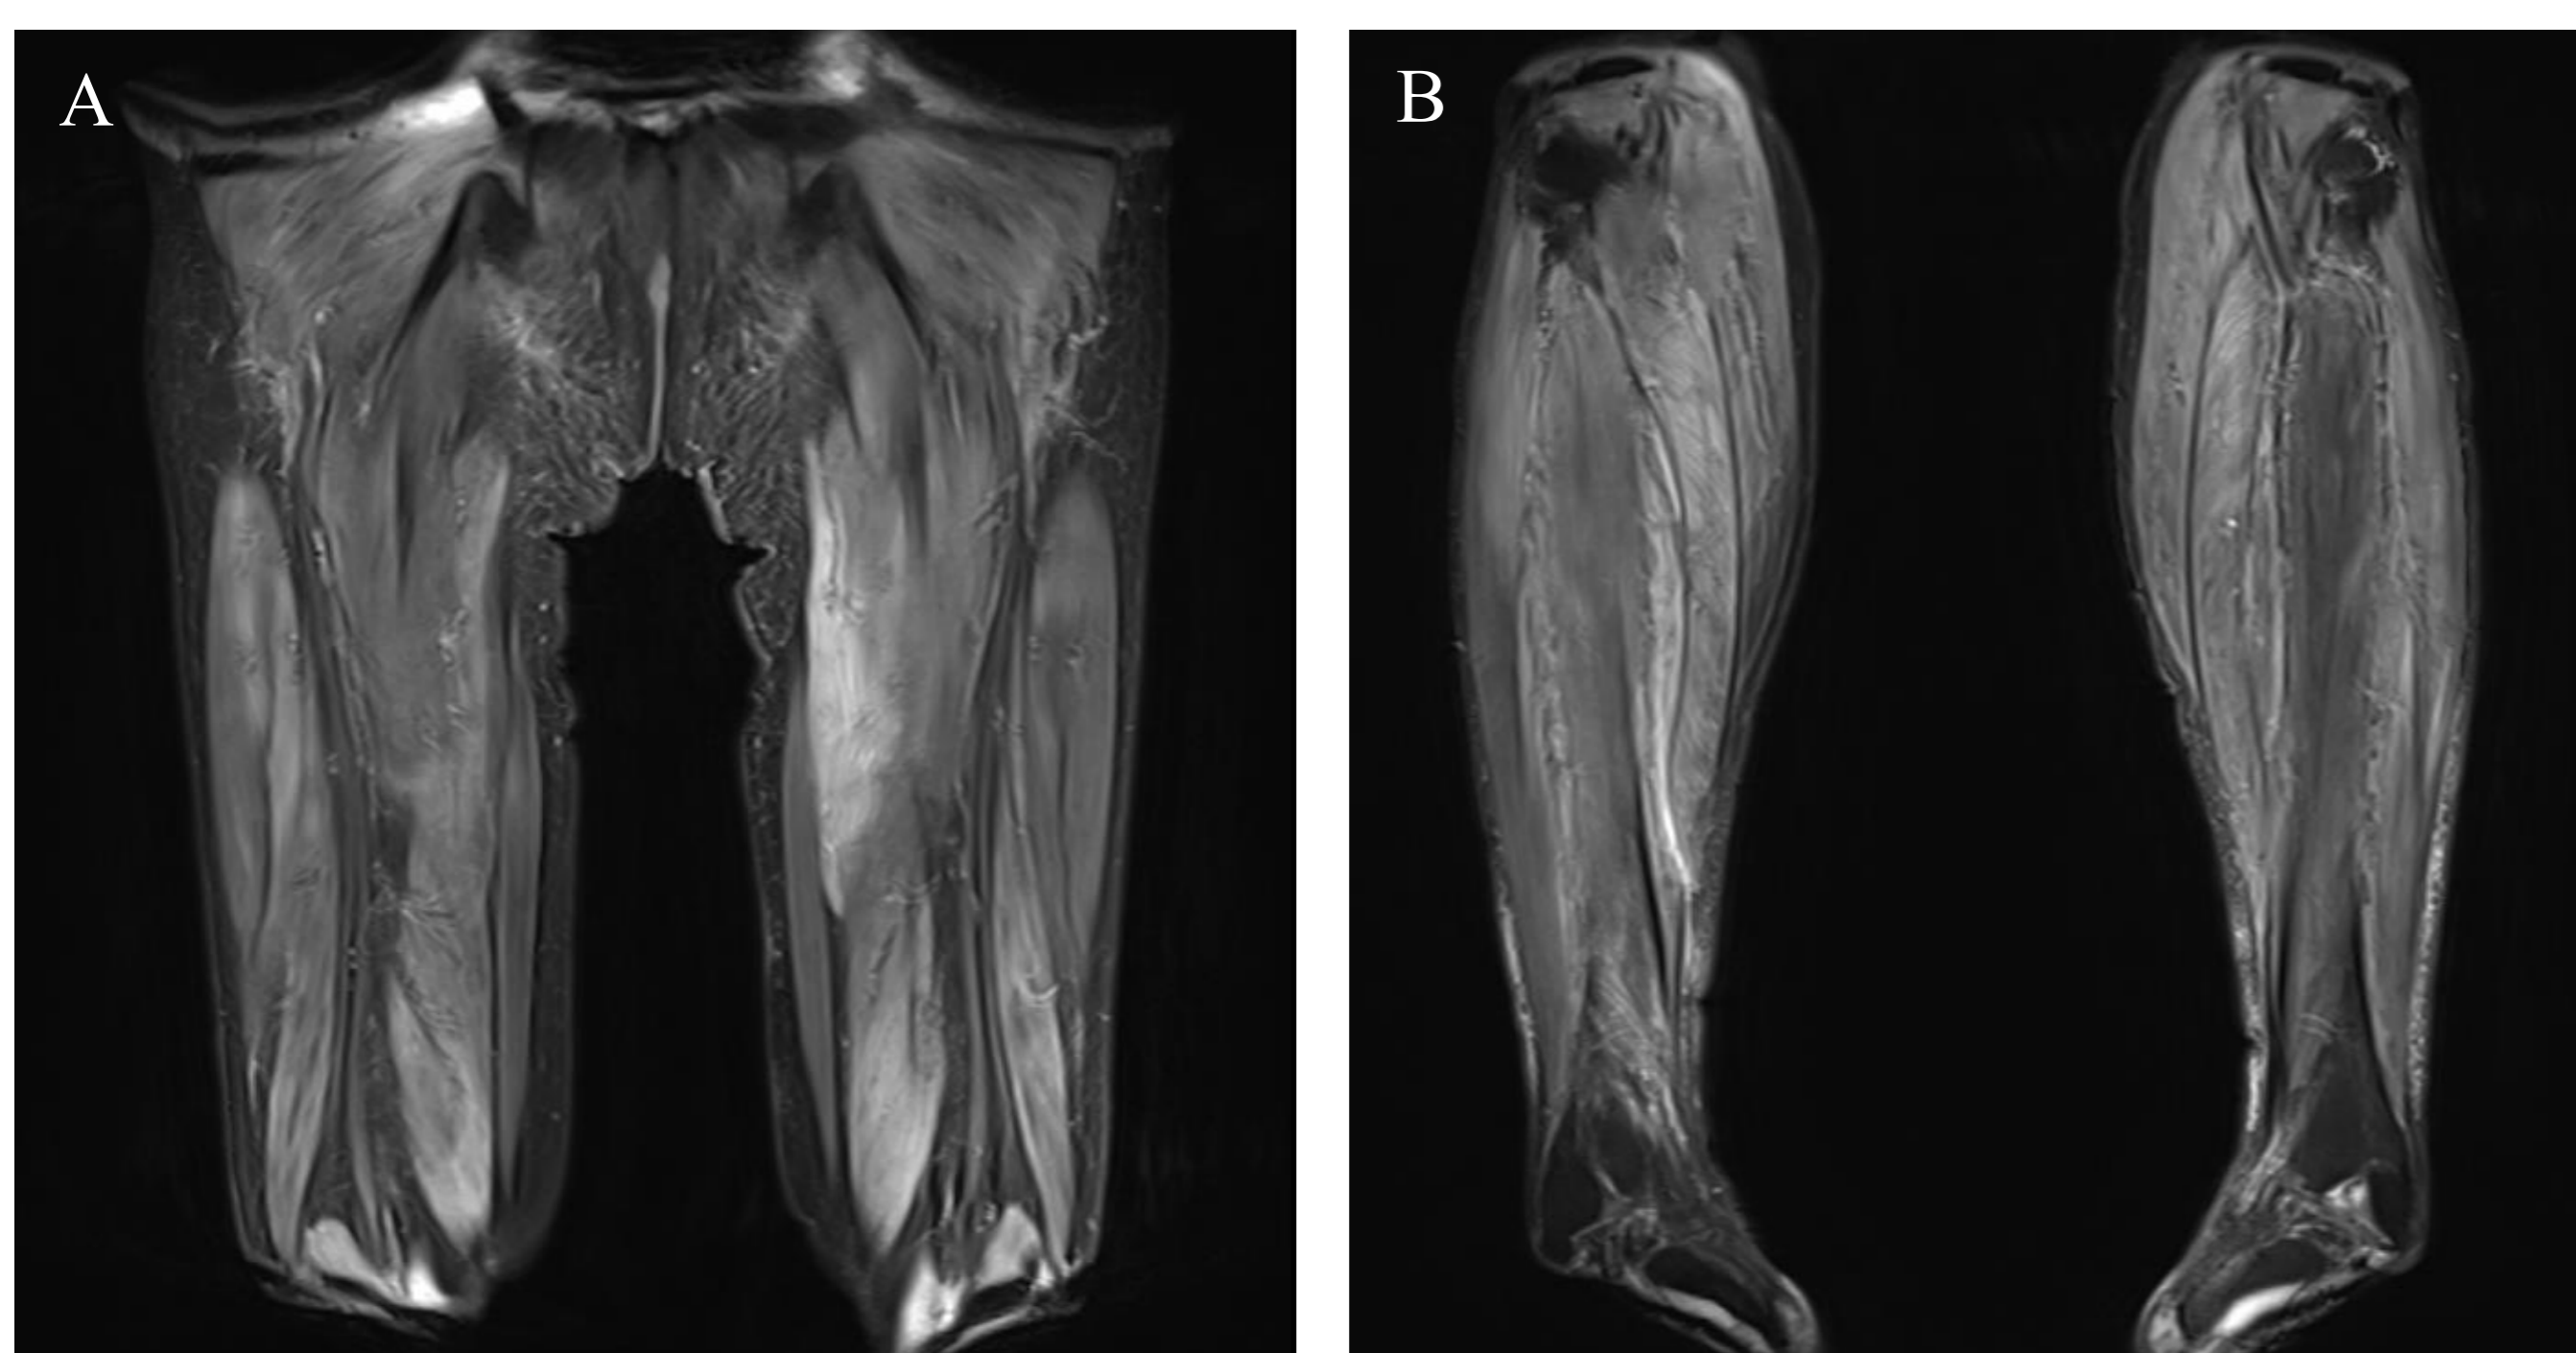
Lower extremity MRI. Coronal thigh (A) and lower leg (B) T2-weighted fat-saturated images show diffuse, symmetrical increased muscle signal intensity from the buttocks to the ankle level involving all compartments, with relatively preserved intermuscular and crural fascial planes and no significant subcutaneous signal change.
